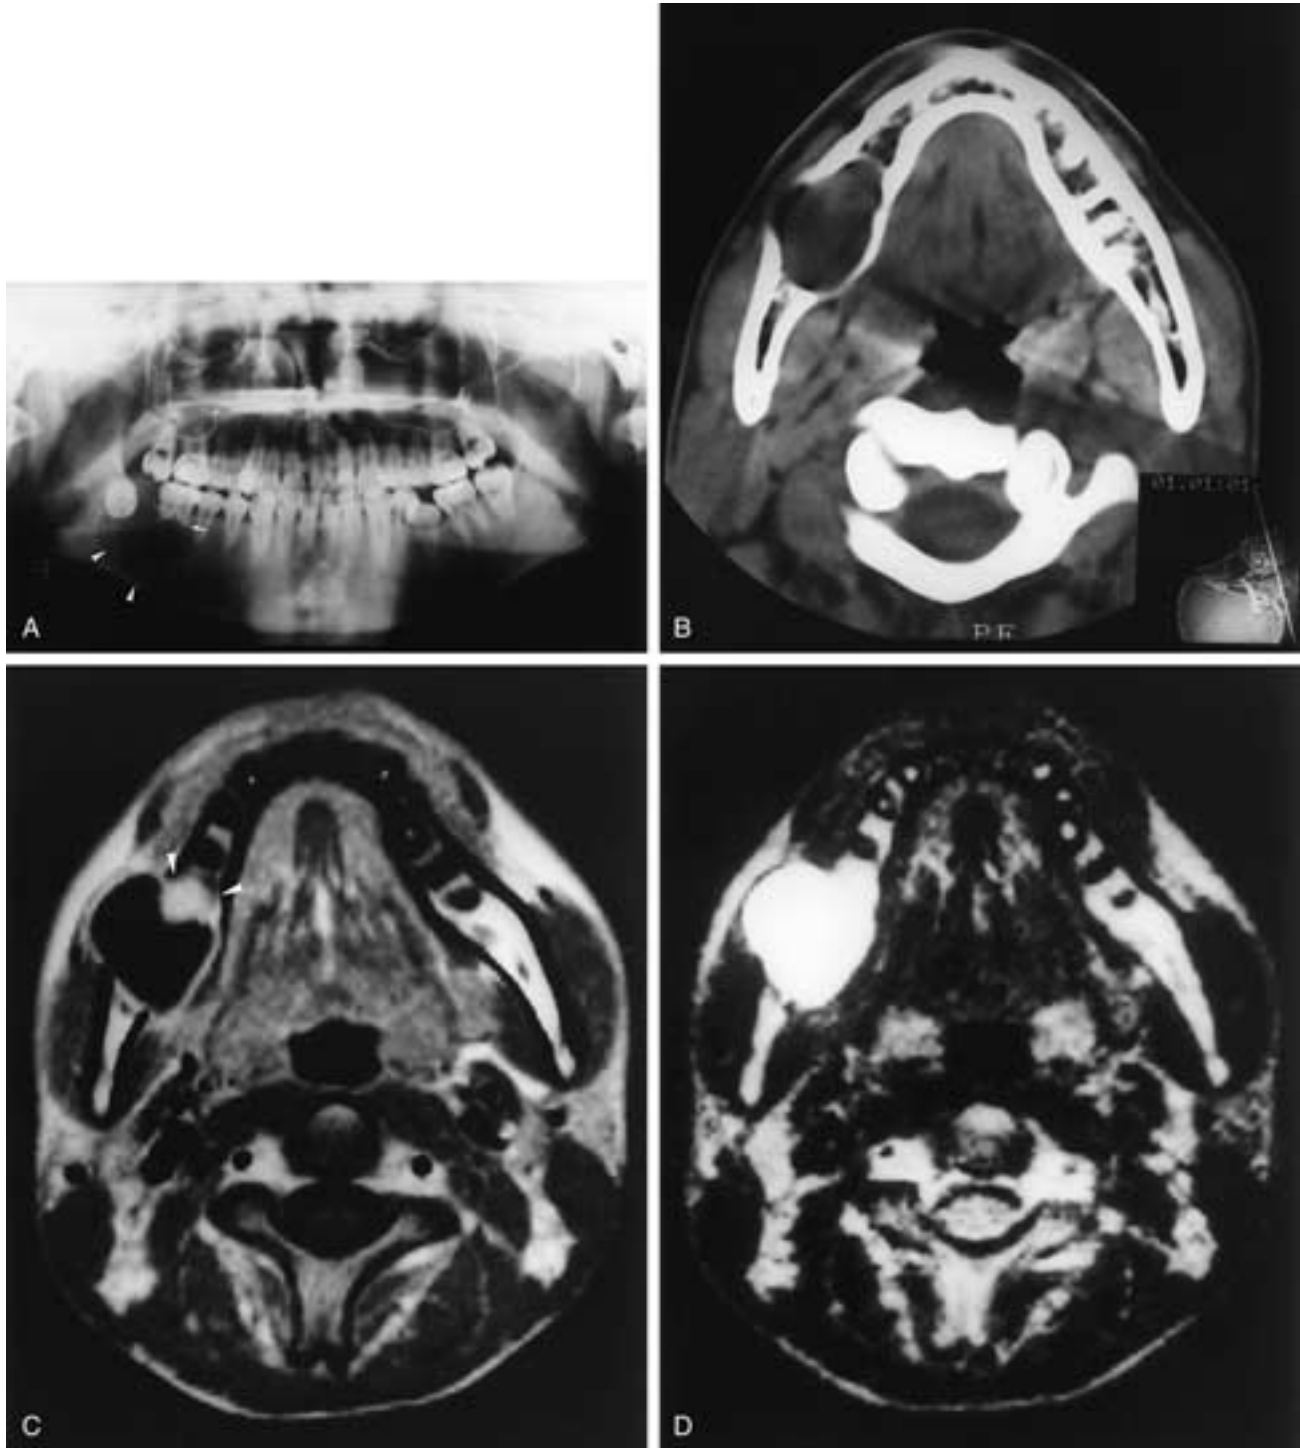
Unilocular ameloblastoma. A, Panoramic radiograph shows a large, unilocular, expansile lesion with an unerupted tooth in the right side of the mandible (*arrowheads*). There is root resorption of adjacent teeth (*arrow*). A cystic lesion is suspected. B, Axial CT shows an expansile unilocular lesion, with bulging of the bony cortex without perforation. C, Enhanced axial MR image shows a papillary projection (*arrowheads*) along the walls of the unilocular lesion. D, Axial T2-weighted MR image reveals the lesion to be of high signal intensity.
